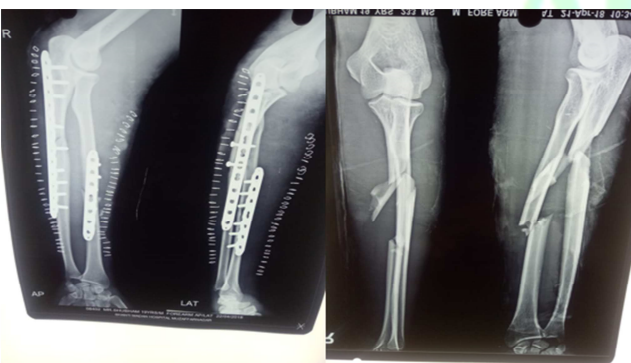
Preoperative and Post-Operative X-Ray of Case 2
